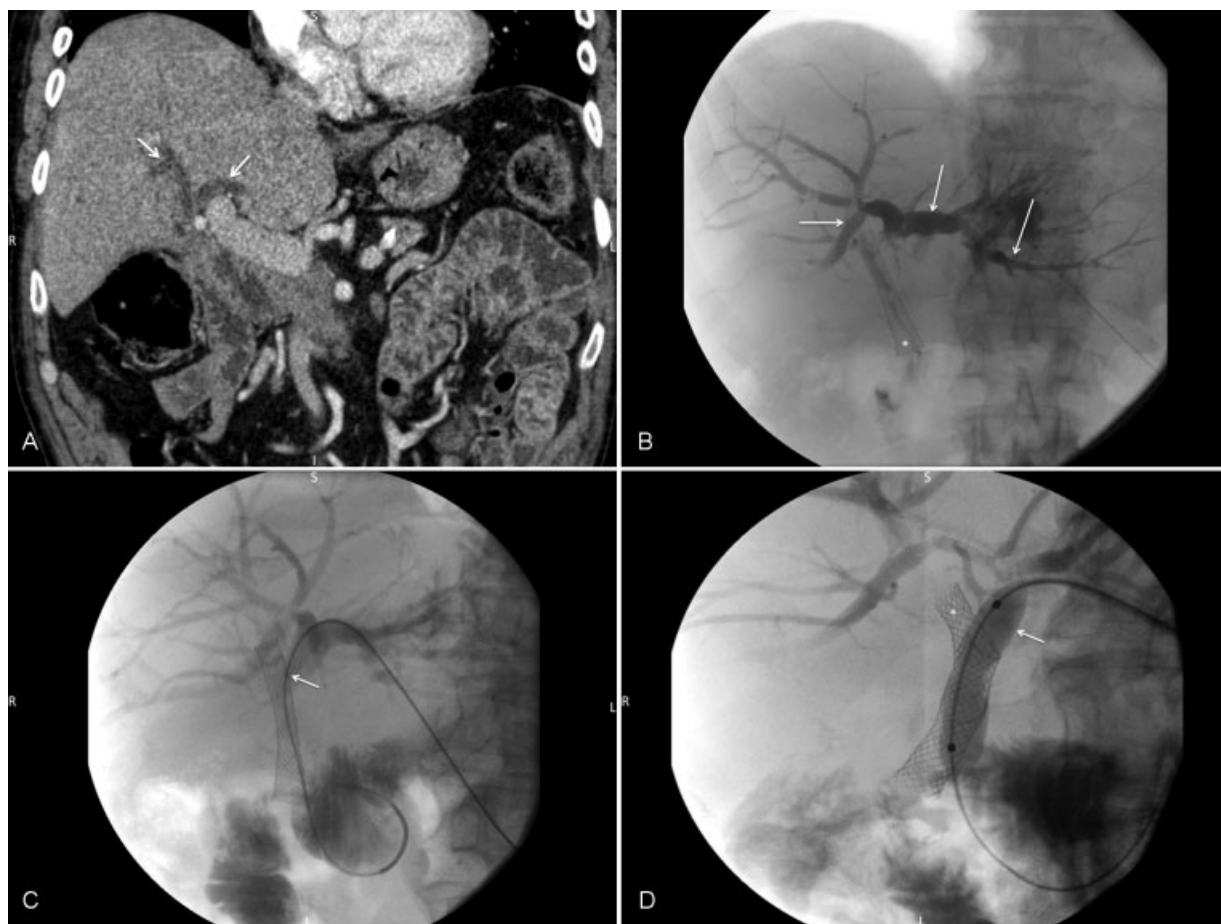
(A) Contrast material-enhanced coronal CT scan in a patient who is s/p Whipple procedure for adenocarcinoma of the pancreas. White arrows point to dilated left and right bile ducts. (B) Percutaneous transhepatic cholangiogram that demonstrates a metal stent with the right hepatic duct (white asterisk) and dilates intrahepatic bile ducts (white arrows). (C) Image from percutaneous cholangiogram that demonstrates a guidewire and catheter that was placed into the biliary stent and the bowel. (D) The fluoroscopic image that demonstrates 10 mm balloon (white arrow) distention of metal stent (asterisk). (E) The fluoroscopic image that demonstrates new metal stent (white arrow) in the left biliary tree that has been placed through an existing right-sided biliary stent. (F) Contrast material-enhanced coronal CT scan in a patient who is s/p Whipple procedure for adenocarcinoma of the pancreas and percutaneous biliary stent placement in a Y-configuration. White arrows point to metal stents within the left and right bile ducts. CT, computed tomography.
